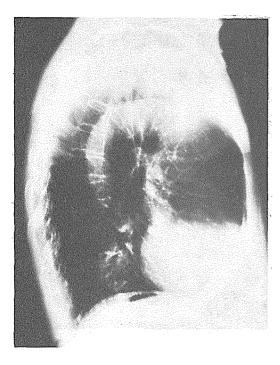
Lateral lung X-ray in January 1991.
